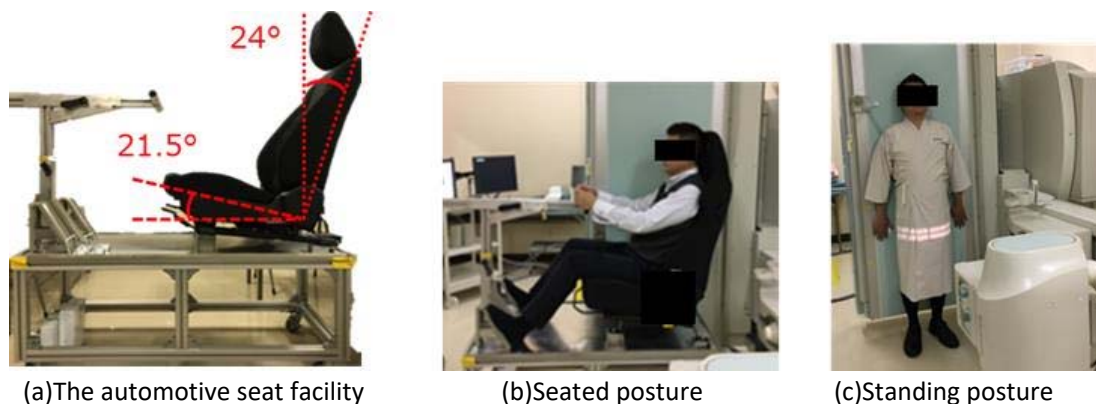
The X-ray facility and situations of X-raying.
